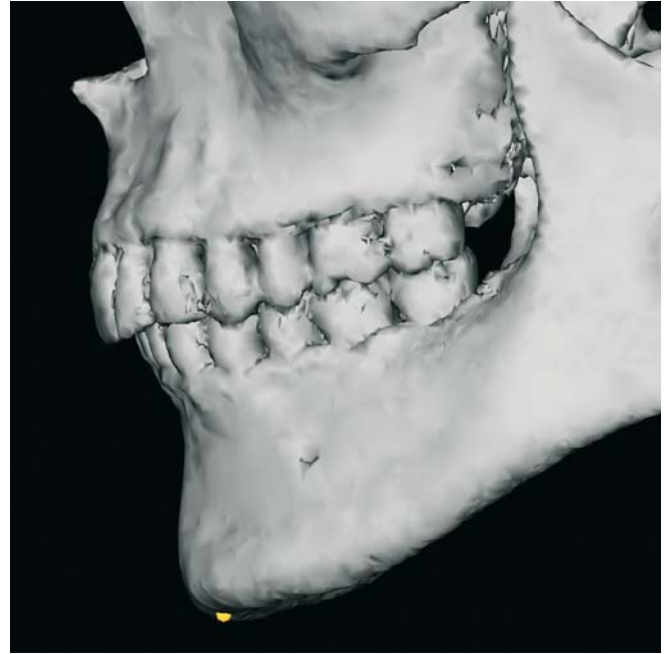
Menton. Profile view left (3-D CT, patient K.C.)
